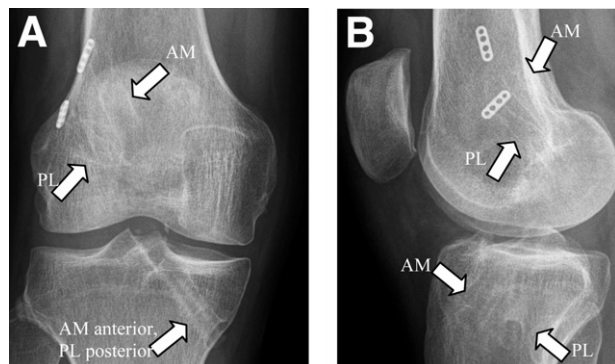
Standardized radiographs with (A) anteroposterior view and (B) lateral view of a double-bundle ACL reconstruction with hamstrings, with two 20-mm EndoButton CL devices for femoral fixation and two bioresorbable 30-mm Milagro interference screws for tibial fixation.
